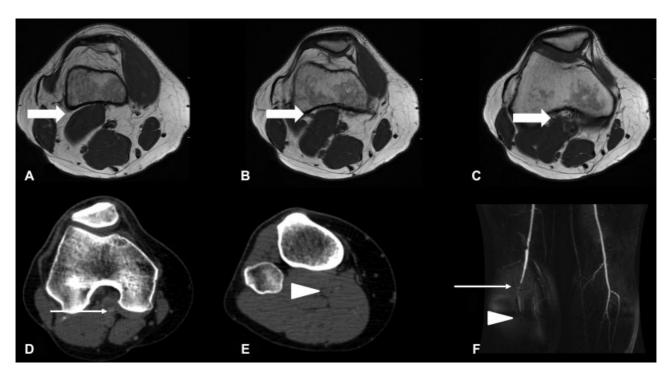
Popliteal artery entrapment syndrome in a 23-year-old non-athlete man complaining of leg pain and cramps during running. T1-weighted axial magnetic resonance imaging (A, B and C), axial computed tomography angiography (D and E) and three-dimensional magnetic resonance angiography (F). Vascular compression in this case occurred due to the superior origin of the lateral head of the gastrocnemius (thick arrow in A, B and C), causing stenosis (thin arrow in D and F) and distal flow occlusion (arrowhead in E and F). In contrast to this case, variants of the medial gastrocnemius are more common.
